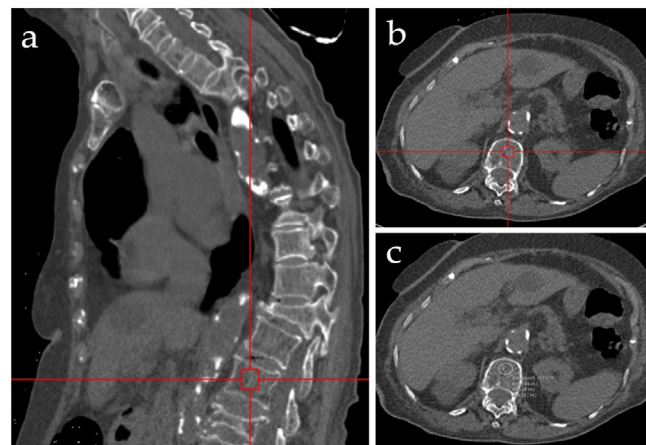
Measurement of L1 trabecular attenuation on non-contrast chest CT. The L1 vertebra is localized using sagittal (a) and axial (b) planes. An elliptical ROI is placed within the anterior trabecular bone (c) to obtain the mean HU value. CT: Computed tomography, ROI: Region of interest, HU: Hounsfield unit
